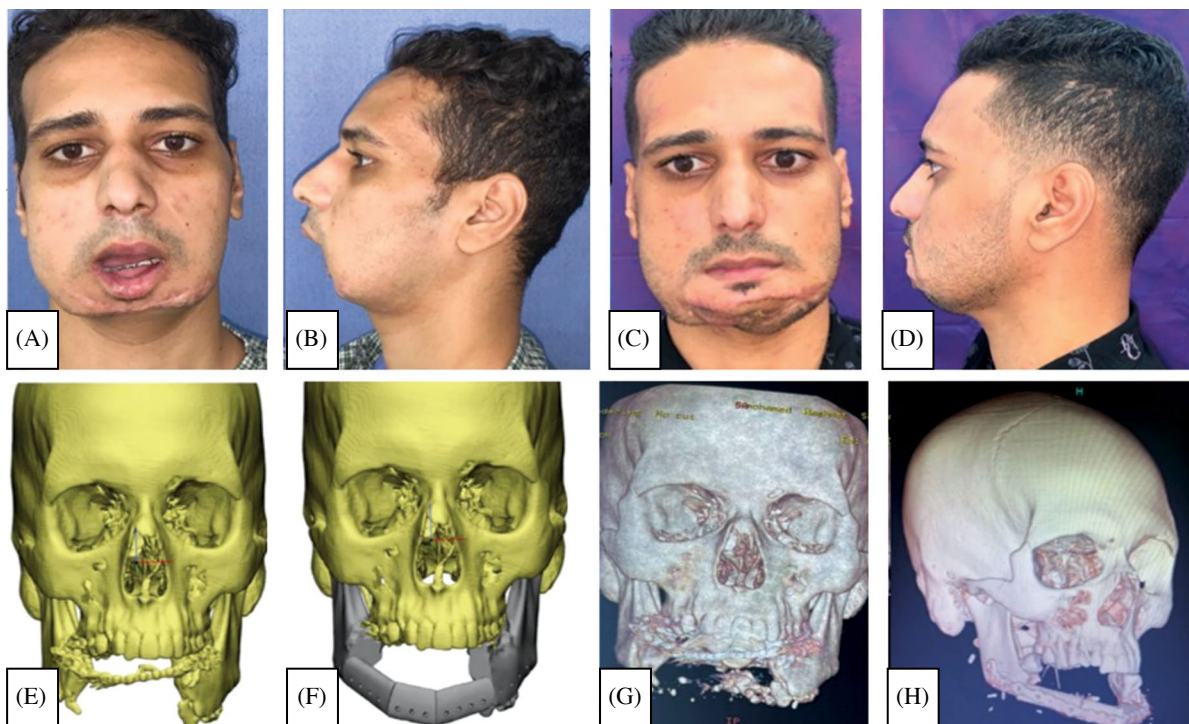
Case (1): (A and B): Pre-operative photos. (C,D): Post-operative photos after 6 months from the reconstruction. (E,F): Pre-operative virtual surgical planning, (G): Pre-operative CT of the patient. (H): Post operative CT of the case.
